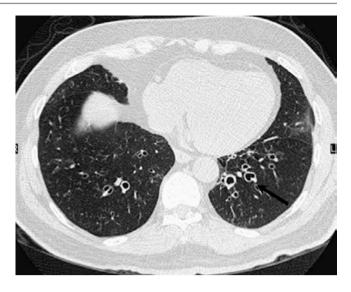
Signet ring sign. Axial CT section showing signet ring sign due to dilated bronchus and normal-sized adjacent vessel (arrow)
